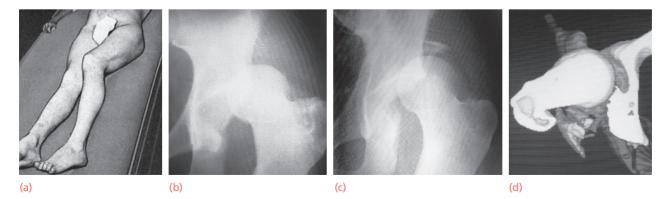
Posterior dislocation of the hip (a) This is the typical posture in a patient with a posterior hip dislocation: the left hip is slightly flexed and internally rotated. (b) The X-ray in this case demonstrates a simple dislocation, with the femoral head lying above and behind the acetabulum. (c) Dislocation and an associated acetabular rim fracture. CT scan helps delineates the acetabular fracture (d).
